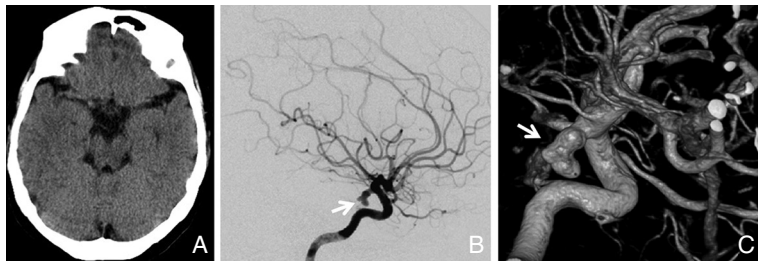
A: An axial computed tomography (CT) scan of the head showing no subarachnoid hemorrhage. B, C: Right carotid angiograms demonstrating an irregularly shaped aneurysm (arrow) at the junction of the internal carotid artery and the posterior communicating artery.
